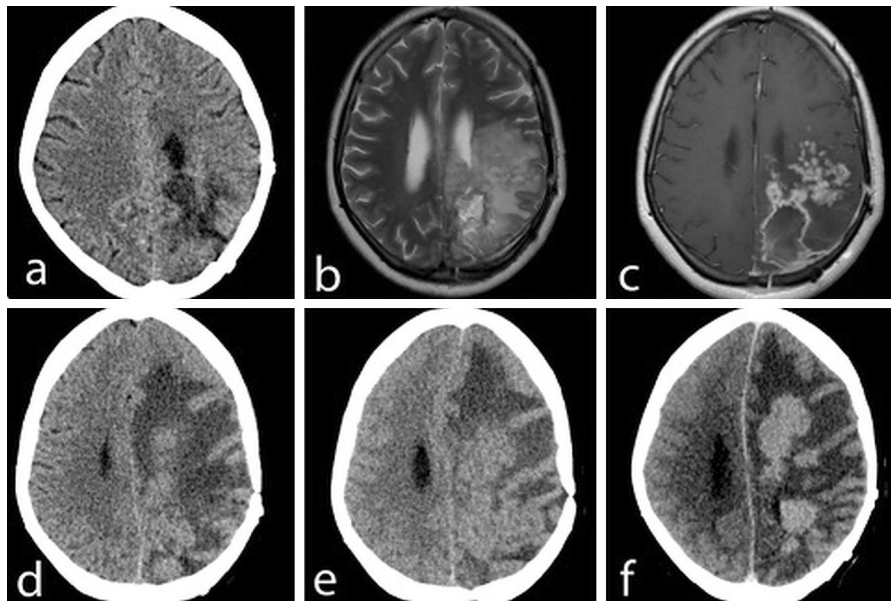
Postoperative NCCT (a) shows the resection cavity with minimal residual mass effect and edema (February 2014). A later MRI (b) revealed a resection cavity with associated edema and T2-isointense nodular lesions (March 2014) that enhanced
